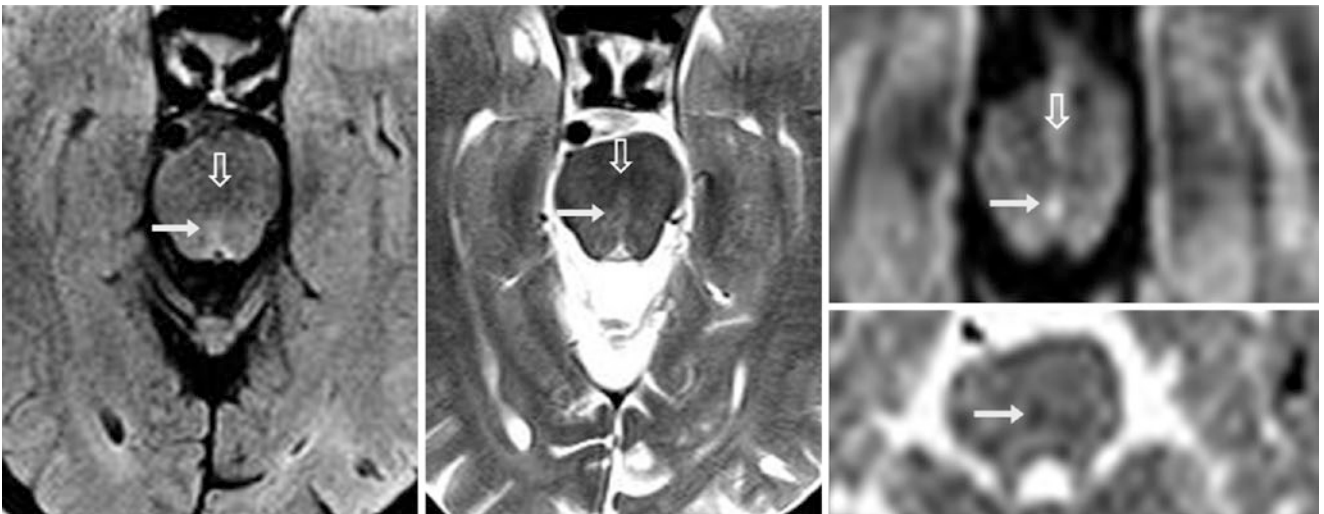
Comparison case of lacunar infarct in a 58-year-old with internuclear ophthalmoplegia. A 1.5 T MRI with FLAIR (*left*) and T2WI (*middle*) depicted a tiny lesion just right of midline, located within the medial longitudinal fasciculus (*arrows*) and just posterior to
